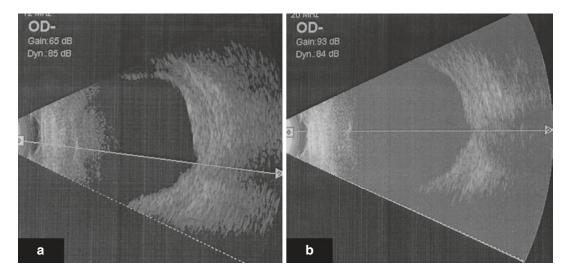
Pre-treatment (a) and post treatment (EBRT) (b) ultrasound images of diffuse choroidal hemangioma. Decrease in choroidal thickness is evident
